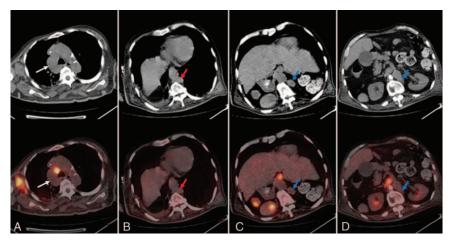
Azygos and hemiazygos continuation of IVC presented on FDG PET/CT. (A) Enlarged azygos arch is paralleling the aorta as it drains into the SVC (white arrow). (B) Enlarged hemiazygos drains into the azygos vein at approximately the ninth thoracic vertebral level (red arrow). (C,D) Enlarged hemiazygos lies on the left side of the aorta (Blue arrow). The intrahepatic portion of the IVC is not identified. Other anomalies including multiple right-sided spleens, right-sided stomach, a short pancreas, PPV, and malrotation of gut were also noted. FDG = fluorodeoxyglucose, IVC = inferior vena cava, PET/CT = positron emission tomography/computed tomography, PPV = preduodenal portal vein, SVC = superior vena cava.
